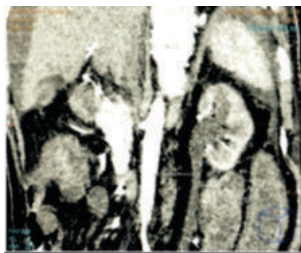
CT Abdomen- Left Hydronephrosis
